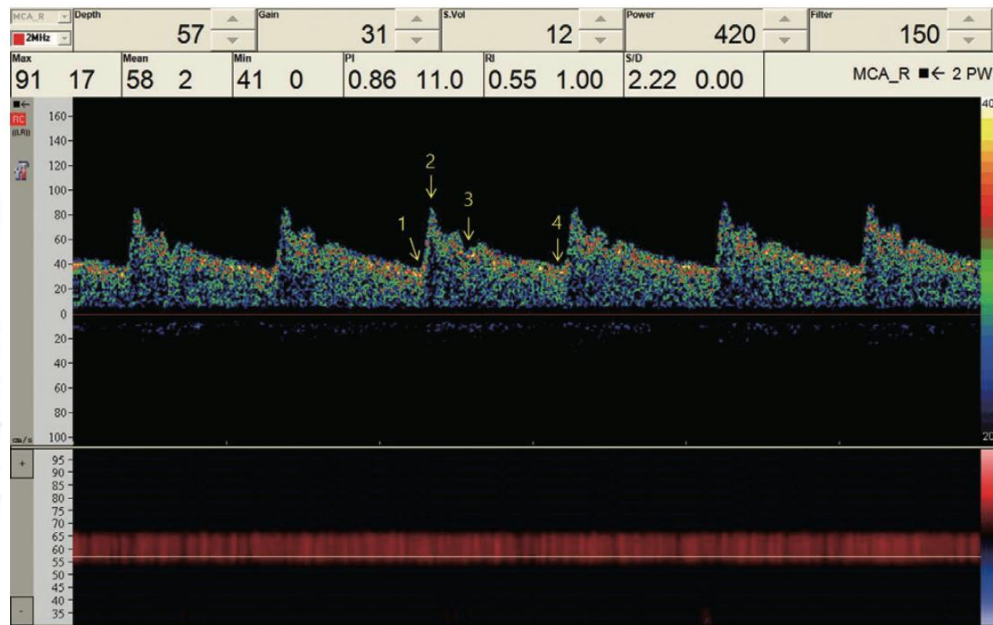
DEMONSTRATION OF NORMAL TRANSCRANIAL DOPPLER SPECTRAL WAVEFORM OF THE MIDDLE CEREBRAL ARTERY.
